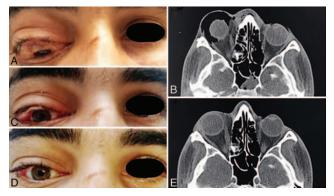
(A) Initial aspect of orbital emphysema, evidencing the proptosis of the right eyeball in addition to the reduced visual acuity. (B) Axial computed tomography showing large orbital emphysema in the right orbit region. (C) Second day and (D) third day emphysema fully regressed. (E) Axial computed tomography in which it is possible to note the presence of orbital emphysema in the right orbit fully regressed.
